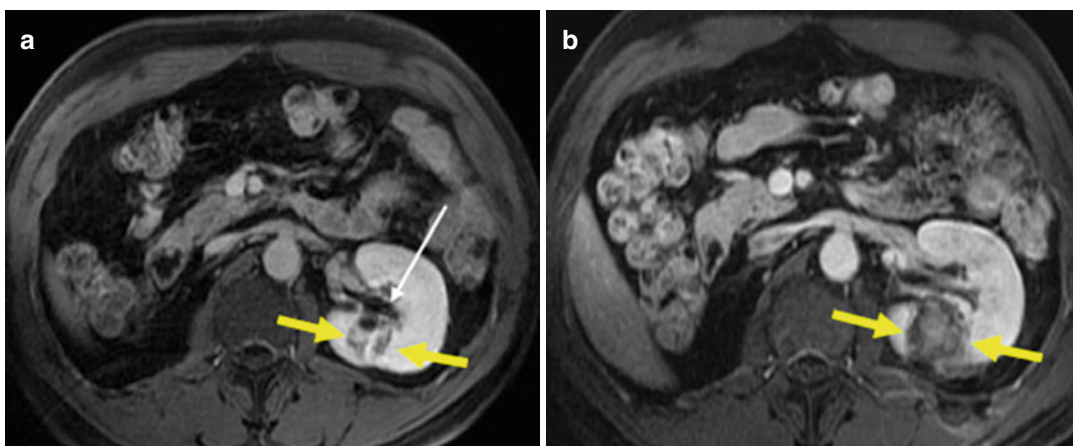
MWA in a 51-year-old man with left RCC, who has a solitary kidney for nephrectomy for right RCC 1 year ago. (a) Preablation MRI scan shows one hypoattenuating neoplasm (short arrow) near the renal pelvis
